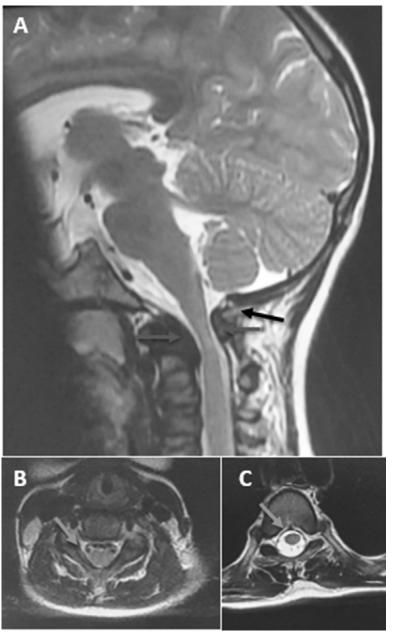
MRI of a 5-year-old child showing in sagittal section (A) the basilar impression secondary to the protrusion of the scale of the occipital bone in the foramen magnum (arrow) and the compression of the spinal cord at the level of C1 (rarrow). The axial section passing through C1 (B) showed the absence of cerebrospinal fluid around the spinal cord (orange arrow) while the axial section passing through the thoracic vertebrae (C) showed a normal appearance of cerebrospinal fluid around the spinal cord (arrow).
